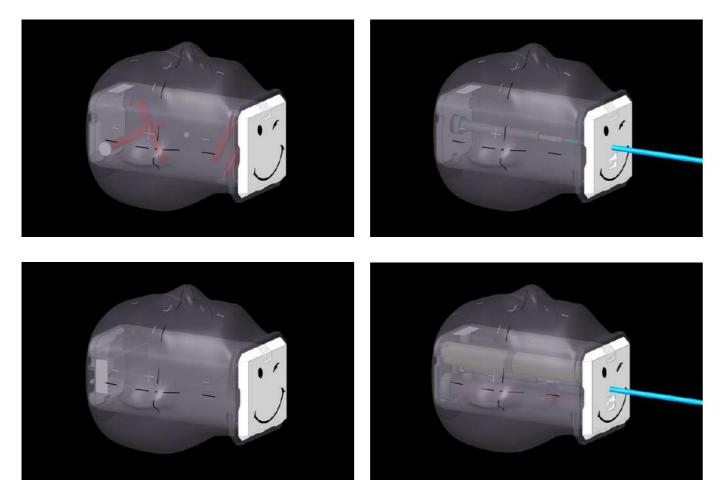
CBCT image registration of the System QA MultiMet insert. Left: Before image registration. Right: After image registration
